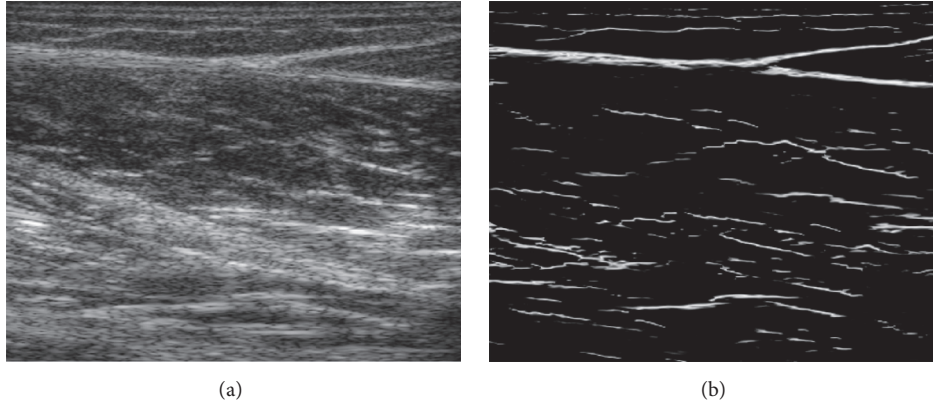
An example showing the oriented phase map: (a) original musculoskeletal ultrasound image contains MTJ; (b) the oriented phase map of the image.
